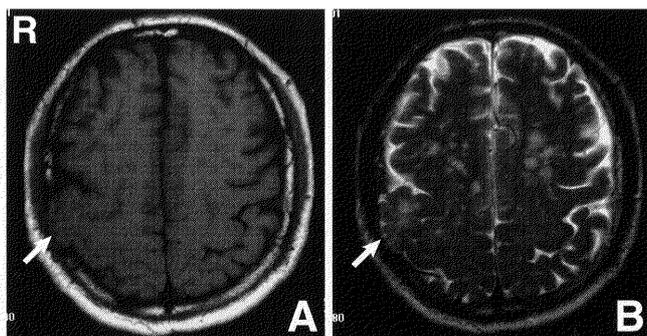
T₁-weighted (A) and T₂-weighted (B) magnetic resonance images showing an isointense lesion (arrow) in the parietal intradiploic space continuous with the right frontal lobe.
